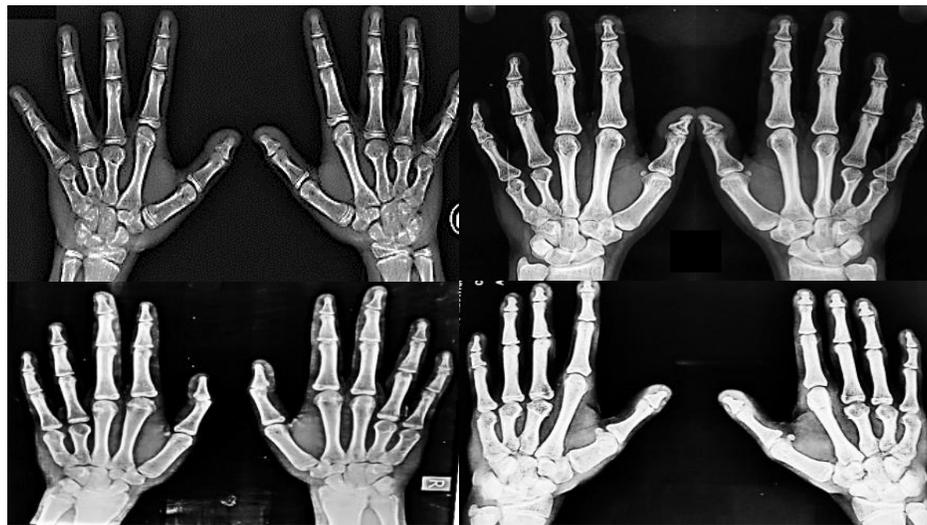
X-ray film of affected individuals of BDE
